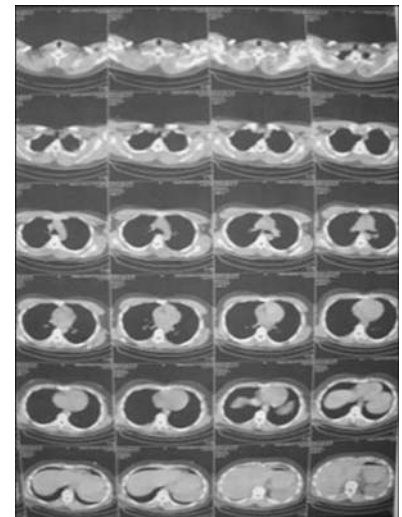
Thoracic CT scan is within normal limits.
